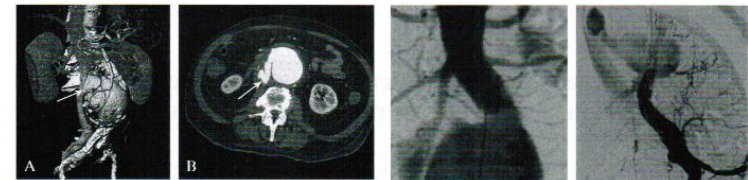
A, B). Preoperative CT scan showing the aortocaval fistula (arrows).
